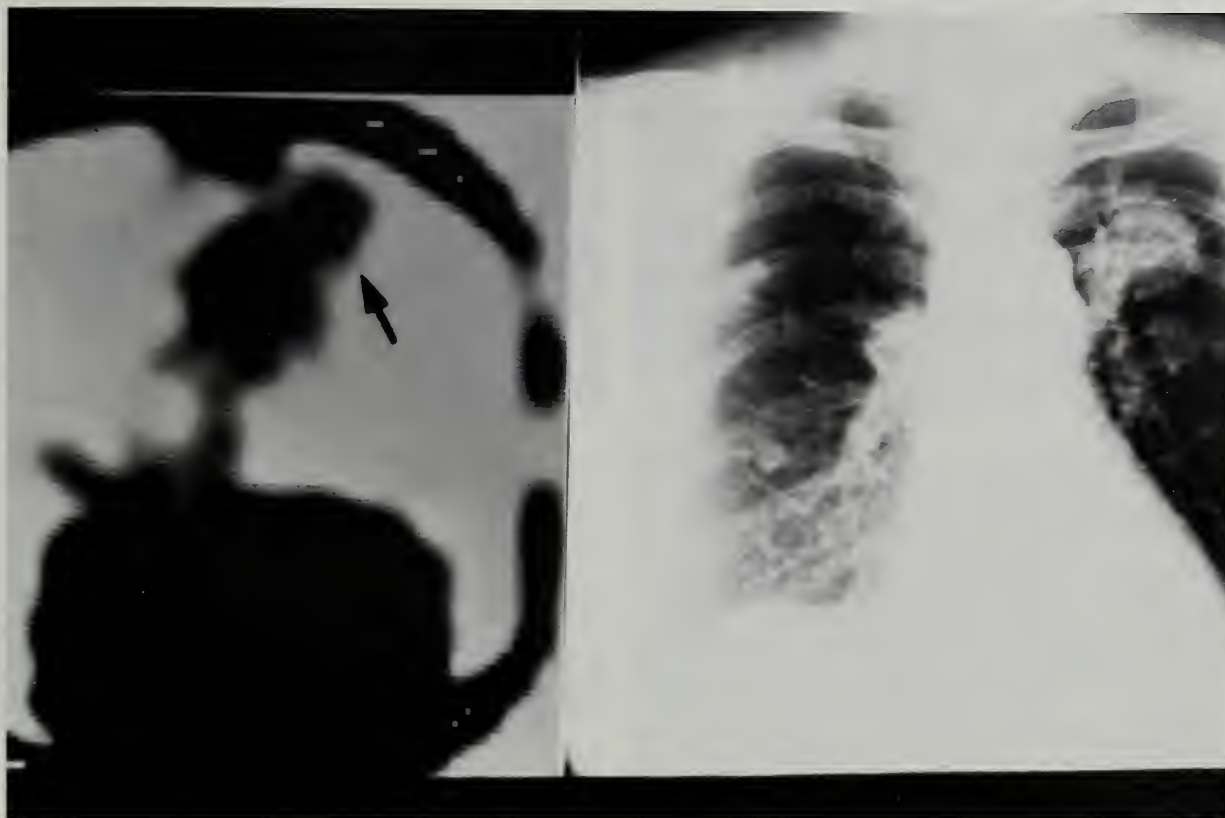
Radioiodinated peanut lectin (iodo-PNA) has been administered to a patient with metastatic cancer of the breast. The scintiscan (left) demonstrates localization of the iodo-PNA in a metastatic lesion extending from the mediastinum, shown on chest x-ray (right).
